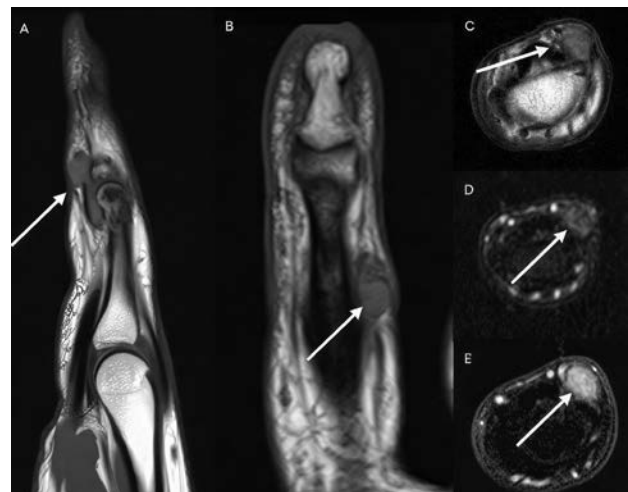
MRI of the finger demonstrates a localized extra-articular TSGCT, arising along the flexor tendon sheath (arrows, A-E). The lesion appears as a well-circumscribed soft-tissue mass with low-to-intermediate signal intensity on T1-WI (arrows, A-C) and on T2-WI fs (arrow, D). The lesion shows heterogeneous enhancement on T1-WI after contrast administration (arrow, E). These findings are typical for localized extra-articular TSGCT and reflect hemosiderin deposition and contrast enhancing cellular stroma within a solid tendon sheath lesion.
